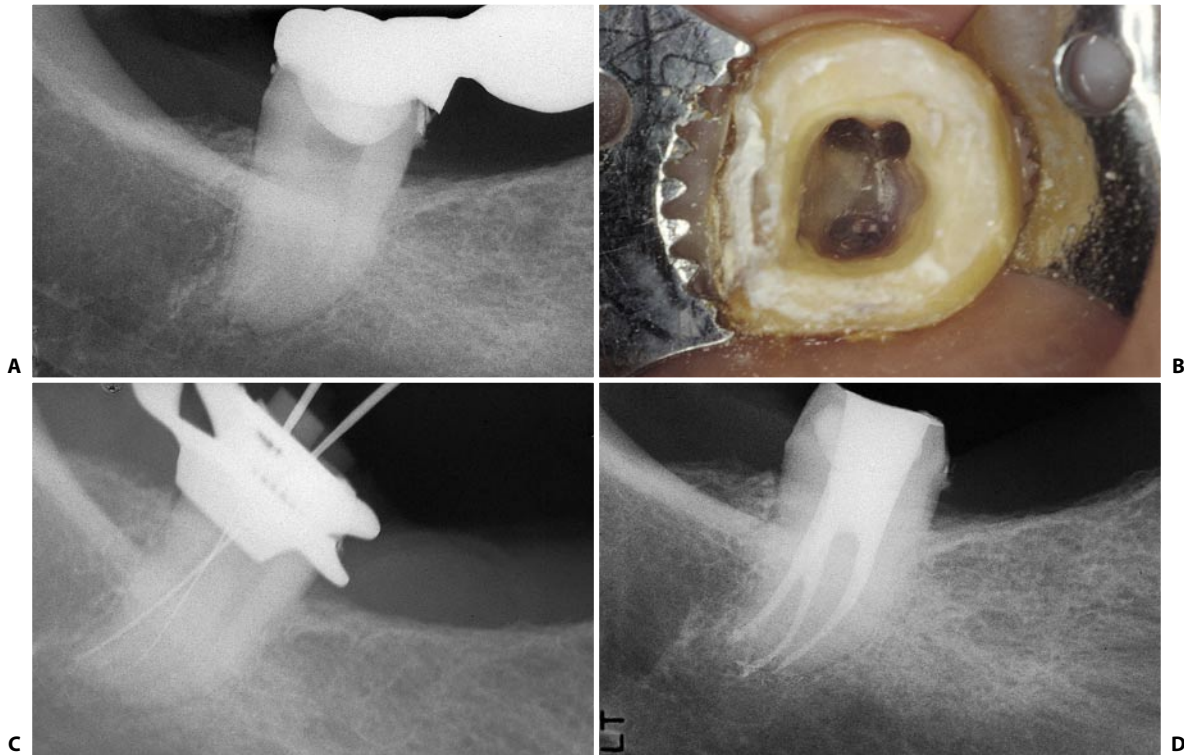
A lower third molar with two distal canals and a single mesial canal. A. Preoperative radiograph. B. Access cavity. C. Intraoperative radiograph. D. Postoperative radiograph.
